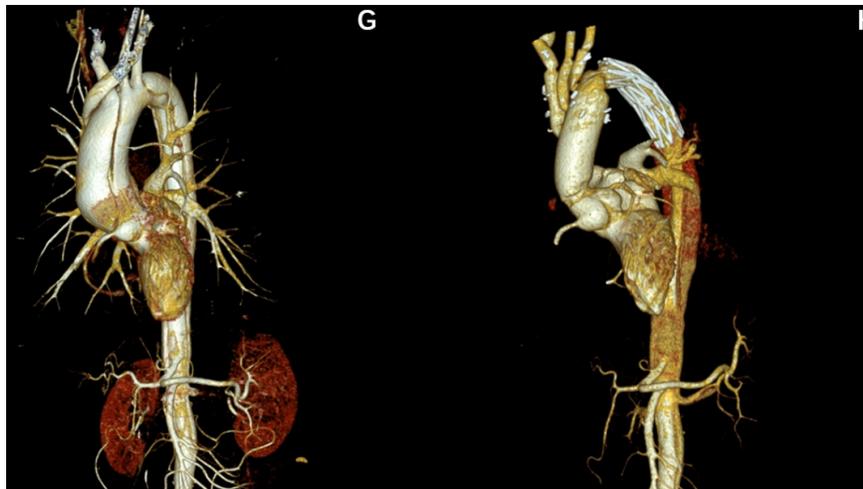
G , a 67-year-old male patient's preoperative computed tomographic angiography (CTA), the dissection involved the aortic root and whole aorta. H , 3-month postoperative CTA with simplified arch-first technique.
